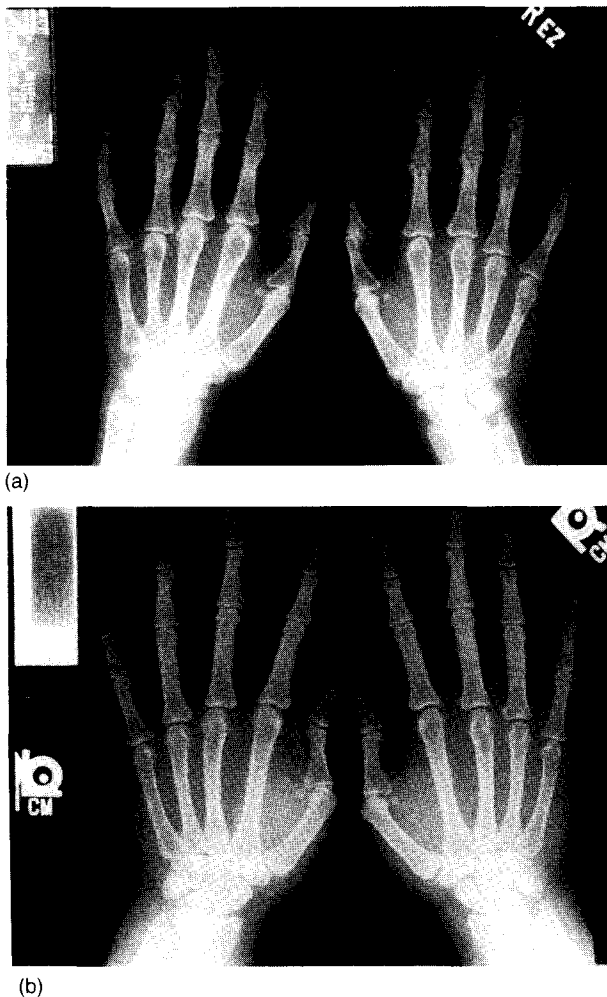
Hand radiographs of (a) a patient with hyperparathyroidism and (b) a normal person.
